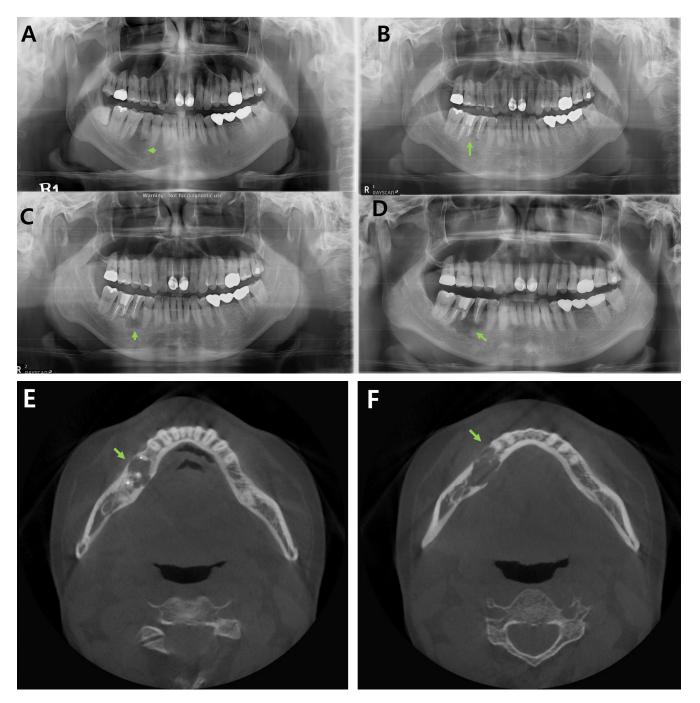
Radiographic image of the right mandibular lesion.
